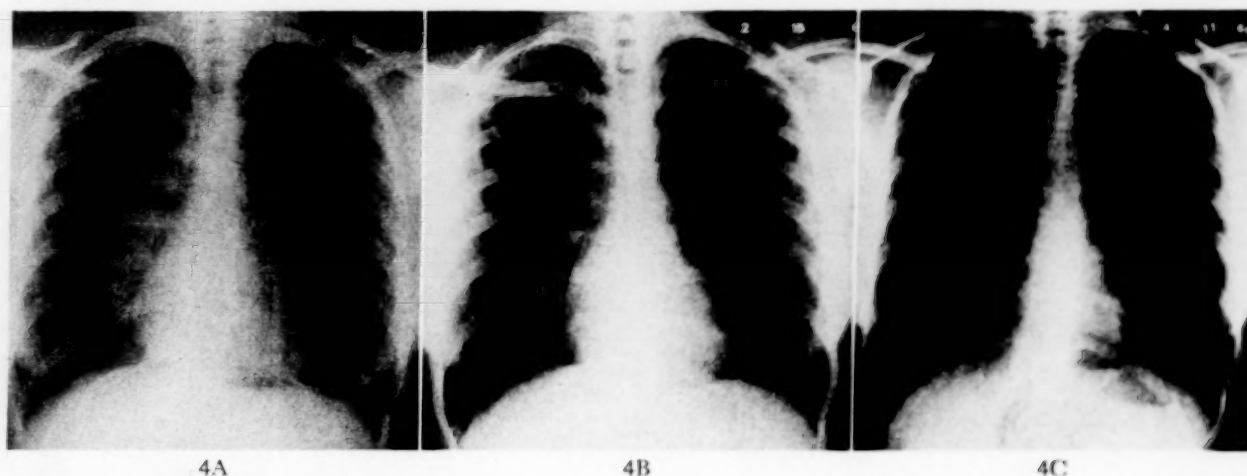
Case VII. Roentgenograms of the chest. A, immediately prior to the administration of chloroquine. B, after four months of chloroquine therapy. C, after five and a half months of therapy.
